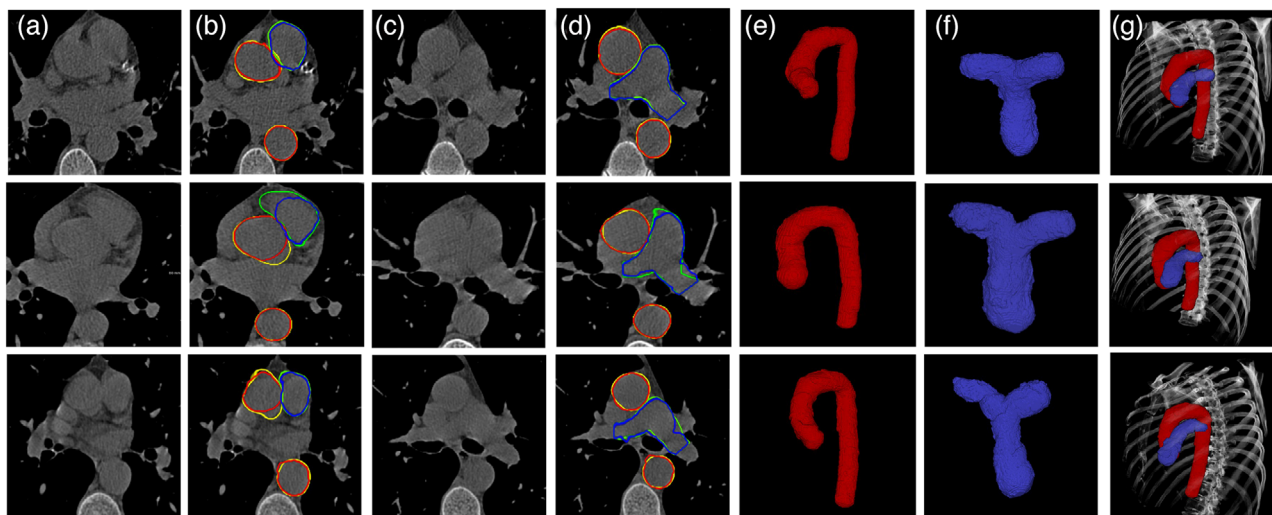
Examples of the obtained segmentations. First row is a good segmentation with $DSC = 0.95$ for PA and $DSC = 0.97$ for the aorta. The next two rows are the two cases with the largest segmentation errors (lowest DSC) for the PA and aorta, respectively, with $DSC = 0.90$, $DSC = 0.96$ for row 2, and $DSC = 0.92$, $DSC = 0.95$ for row 3. Column (a) shows an axial slice close to the heart and column (c) shows a slice at pulmonary artery bifurcation level. In columns (b) and (d), the manual PA (green) and aorta (yellow) are overlaid with the automatic segmentation of the PA (blue) and aorta (red). The 3D segmentation of the aorta (e) and PA (f) is shown together with the 3D view of the CT scan in (g)
